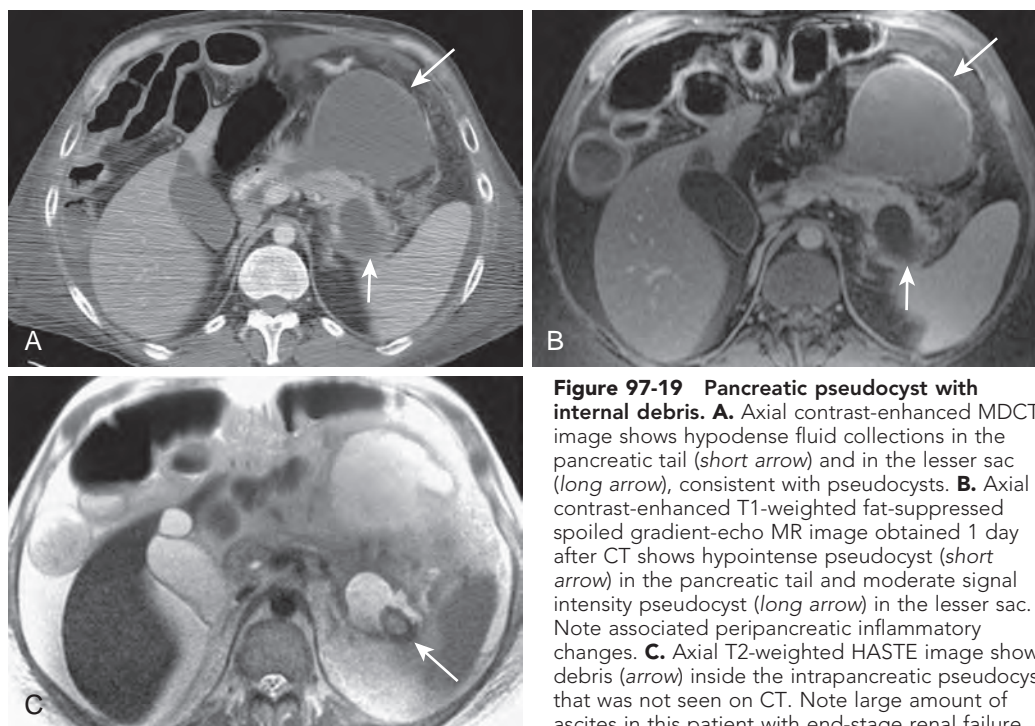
Pancreatic pseudocyst with internal debris. A. Axial contrast-enhanced MDCT image shows hypodense fluid collections in the pancreatic tail (*short arrow*) and in the lesser sac (*long arrow*), consistent with pseudocysts. B. Axial contrast-enhanced T1-weighted fat-suppressed spoiled gradient-echo MR image obtained 1 day after CT shows hypointense pseudocyst (*short arrow*) in the pancreatic tail and moderate signal intensity pseudocyst (*long arrow*) in the lesser sac. Note associated peripancreatic inflammatory changes. C. Axial T2-weighted HASTE image shows debris (*arrow*) inside the intrapancreatic pseudocyst that was not seen on CT. Note large amount of ascites in this patient with end-stage renal failure.
